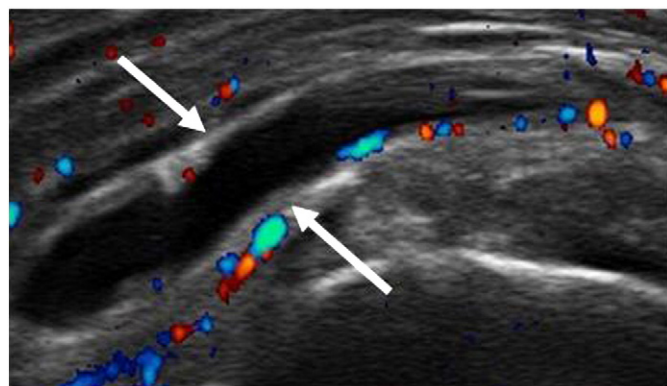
Ultrasonography: coronal view of the shoulder of a patient with active polymyalgia rheumatica showing marked distension of the subacromial bursa (arrows).
